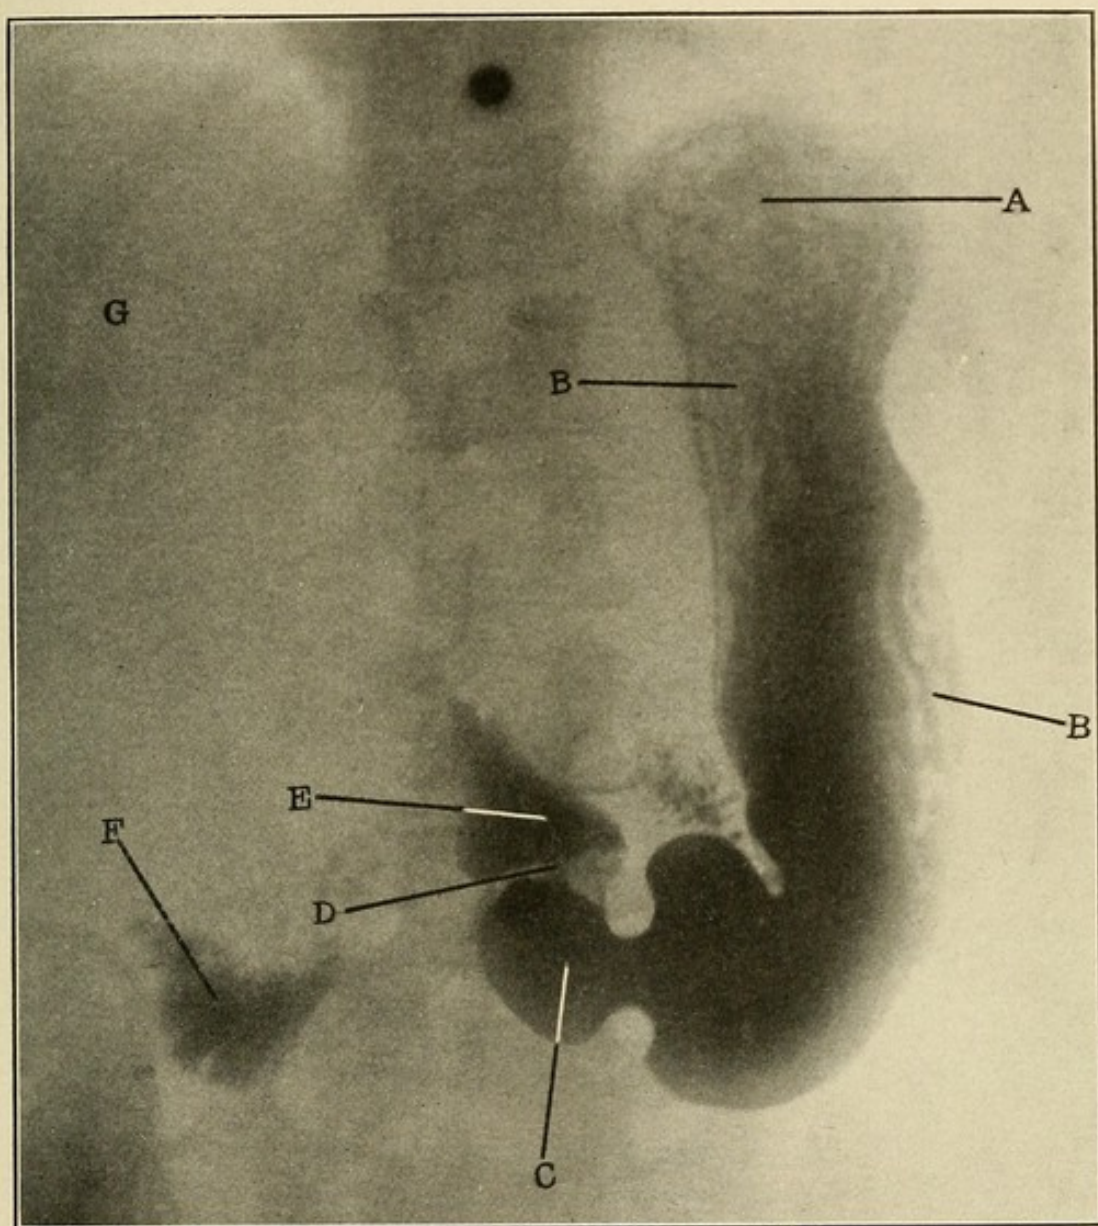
Gastroptosis (moderate) with hypermotility. (*Made in the X-ray laboratory of Dr. Anthony Bassler, New York City.*)
